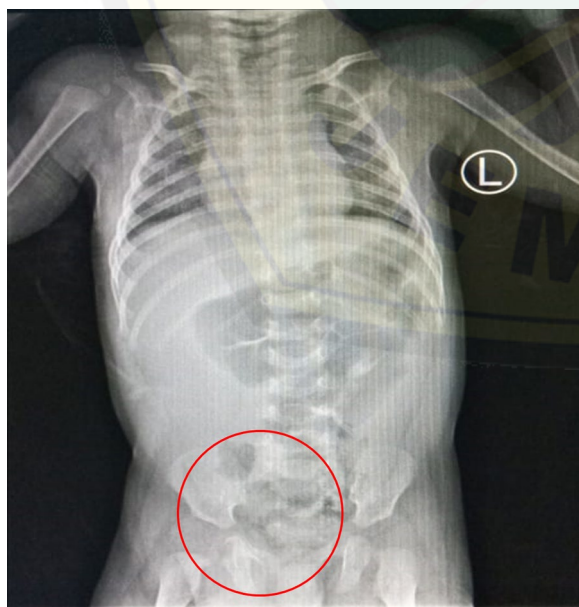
Plain abdominal radiography
